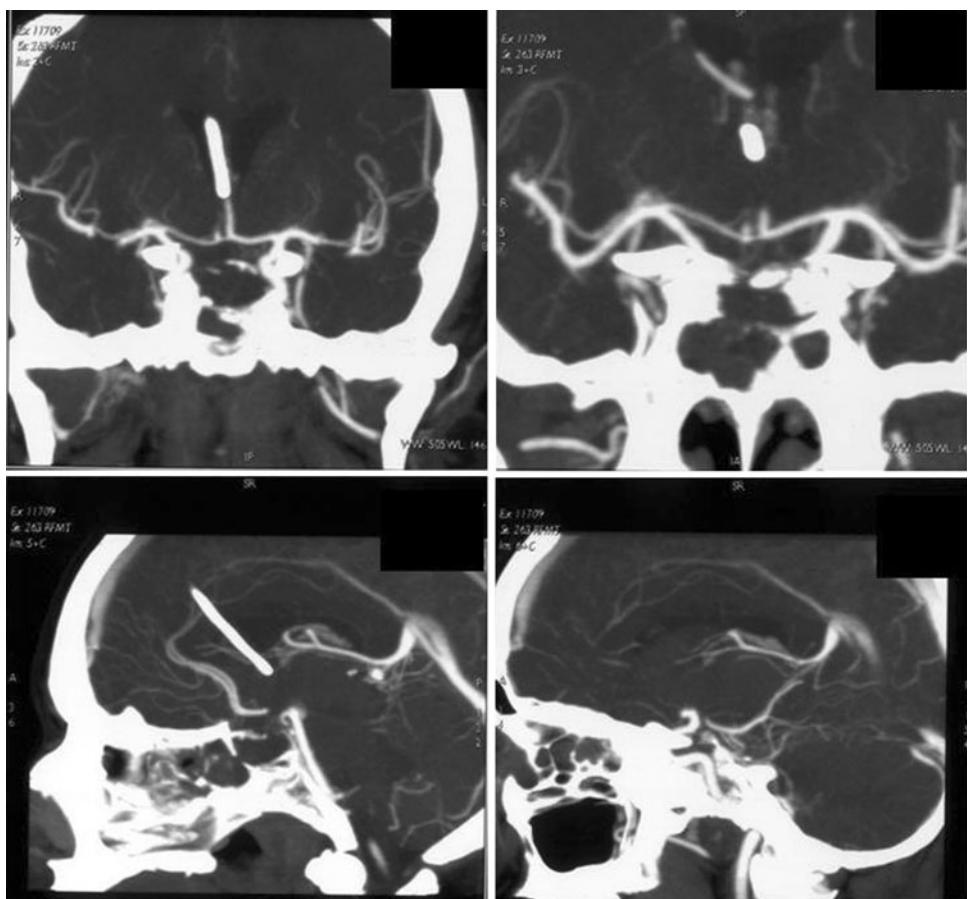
MRI before operation (second case)
